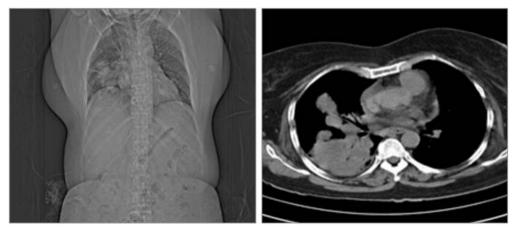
A) CT topogram of the chest reveals right lower lobe consolidation B) right lower and middle lobe consolidation.
